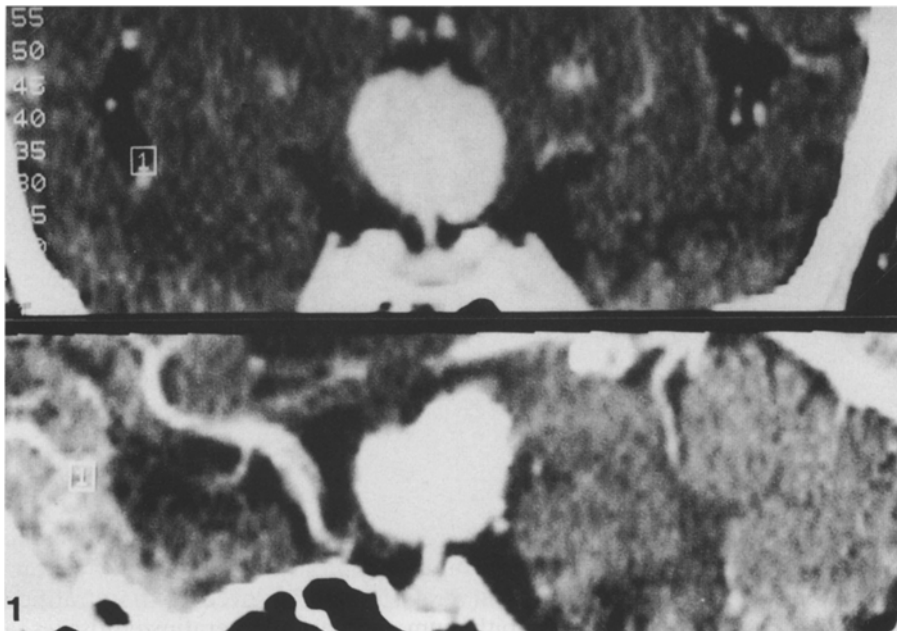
Postcontrast coronal (*upper*) and sagittal (*lower*) reconstructed high resolution CT disclosed the solid and well enhanced mass in the third ventricle
